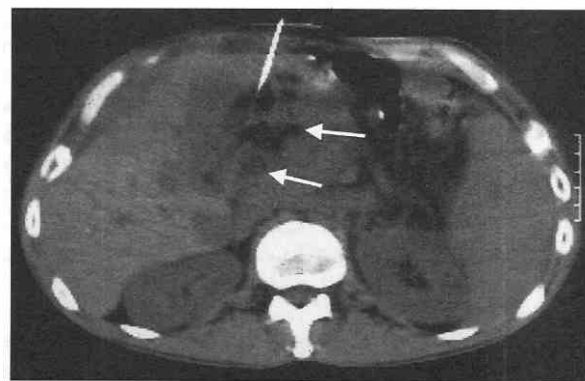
CT scan shows injection of alcohol into a large mass in the epigastrium. Note the distribution of alcohol is irregular (arrows). Because the distribution is so irregular, effective treatment of large tumors is difficult.
